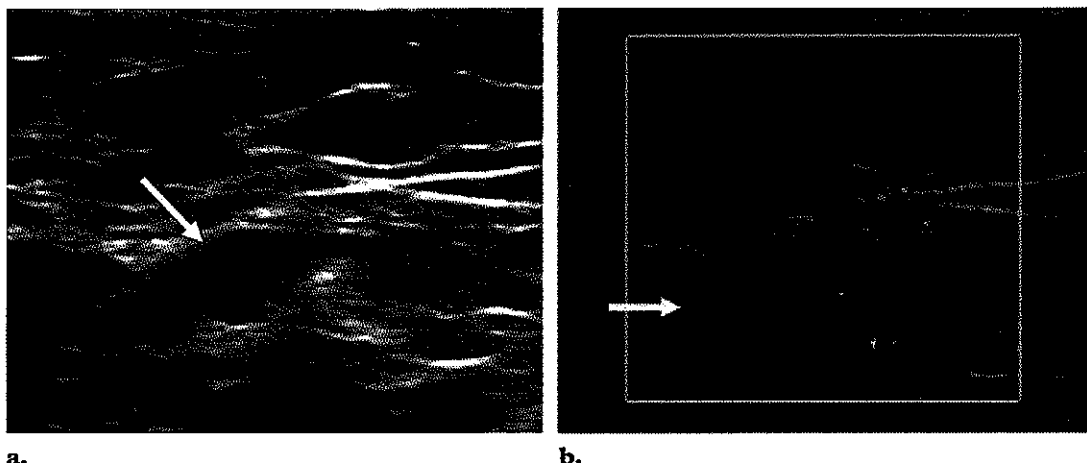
(a) US image shows an abnormal lymph node with asymmetric cortical thickening (arrow). (b) Color Doppler US image shows normal hilar blood flow as well as abnormal (nonhilar cortical) blood flow (arrow), with the latter finding probably representing enlarged capsular vessels.
